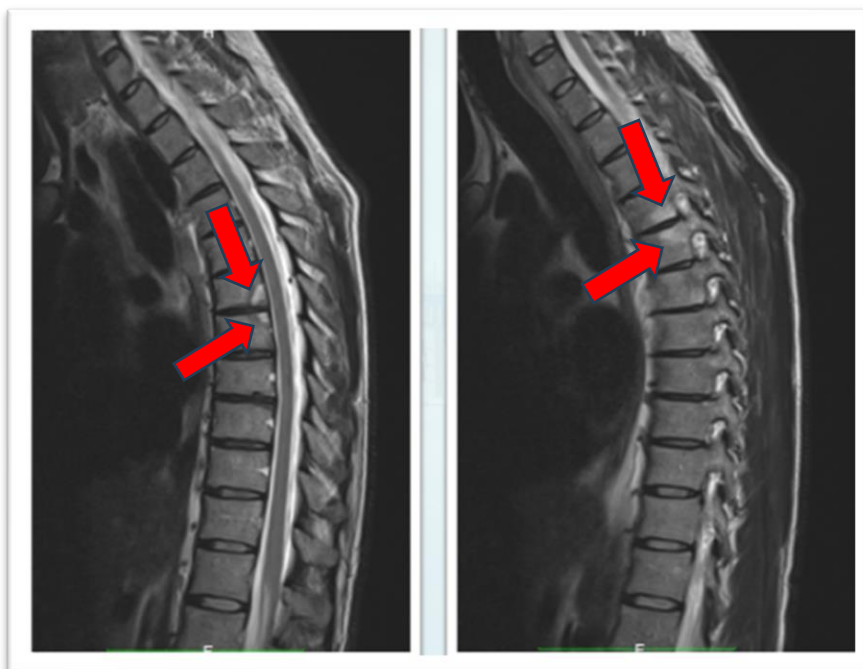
Sagittal T2 MRI: areas of high signal intensity at the level of the posterior edges facing some medium-dorsal metameris (arrows).*
